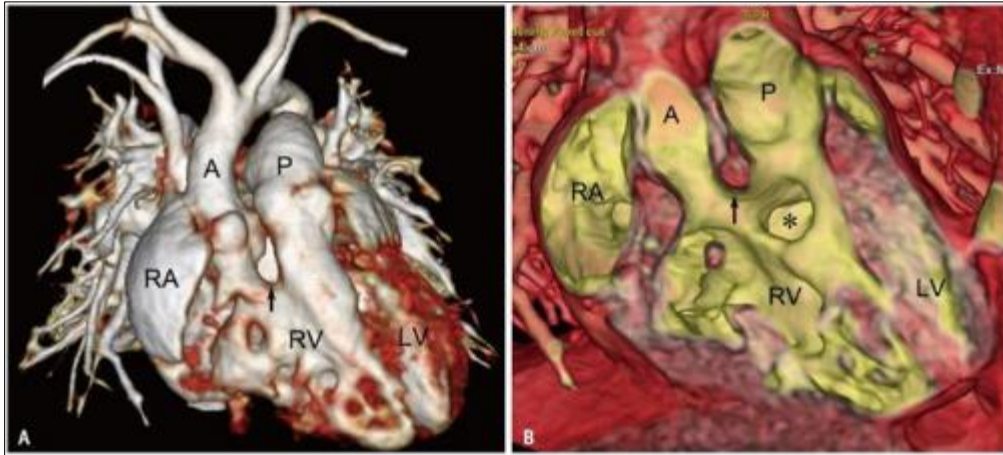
Double outlet RV with non-committed VSD in a neonate. A, B. Standard (A) and transparent-lumen (B) volume-rendered CT images show that both great arteries are connected to the morphologic RV. The non-committed VSD (asterisk) is far from both arterial valves but closer to the pulmonary valve than the aortic valve. The muscular outlet septum (arrows) is noted. A = ascending aorta, LV = left ventricle, P = pulmonary artery, RA = right atrium, RV = right ventricle, VSD = ventricular septal defect
